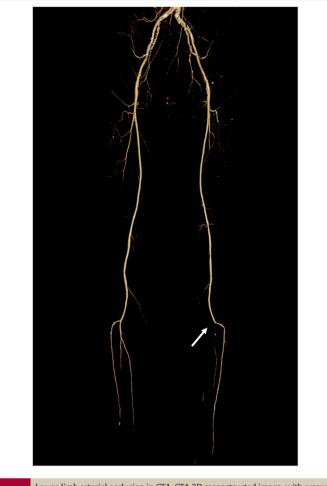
Lower limb arterial occlusion in CTA. CTA 3D reconstructed image, with arrow showing occlusion of left posterior tibial artery. CTA, computed tomography angiography.
